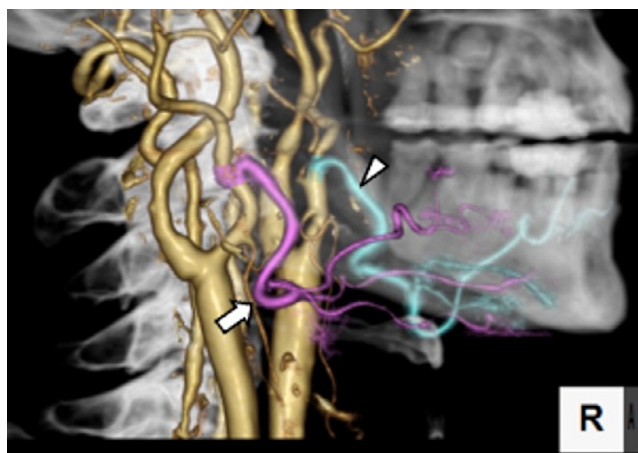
Volume-rendered image created from computed tomography aortography shows the right facial artery (arrow, pink color) and the left facial artery (arrowhead, light blue color) feed the tumor.
